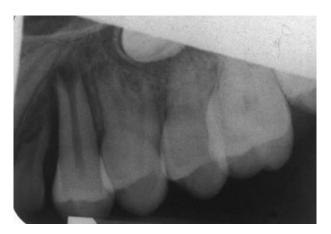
Periapical of upper left anterior region 1 month after transplant, transplanted tooth shows an open apex and enlarged periodontal space.
